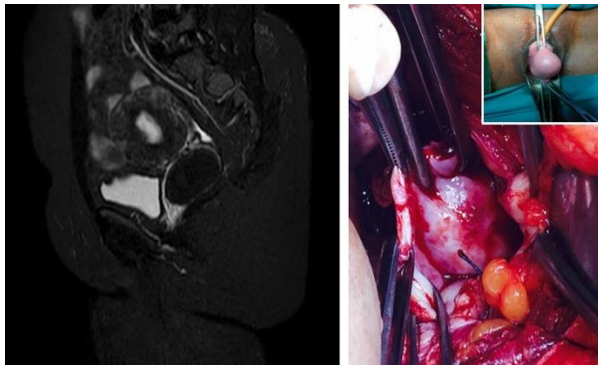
Left image shows MRI images of second case; right panel shows operative image of uterine leiomyoma trans-abdominally (inset shows vaginal counterpart)
